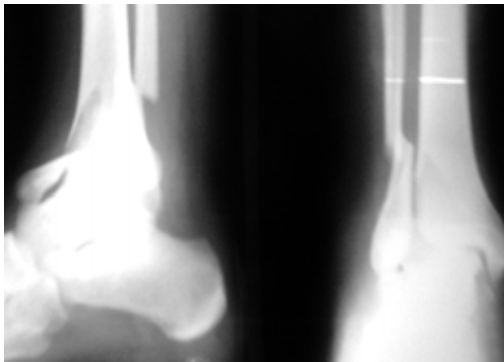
X-ray of ankle showing pronation dorsiflexion injury. Note large chip of anterior tibial articular surface lying in front of the ankle.
